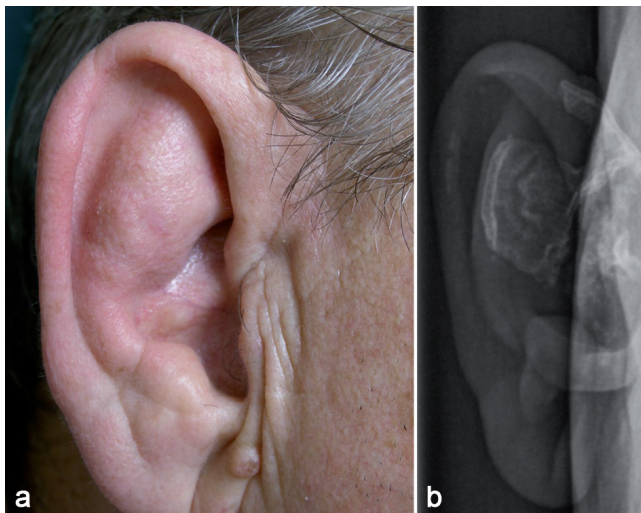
(a) Petrified right ear with normal external appearance. (b) Radiograph of the external ear revealing calcification of the auricular cartilage.
